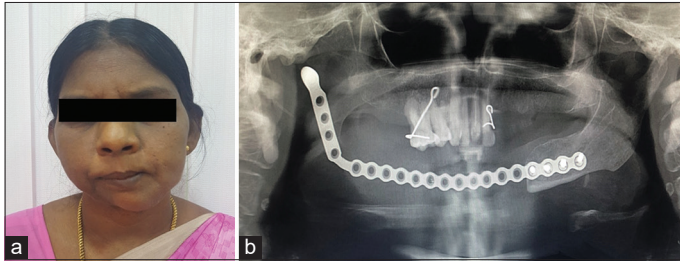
Six months (a) post-operative image and (b) post-operative orthopantomogram
